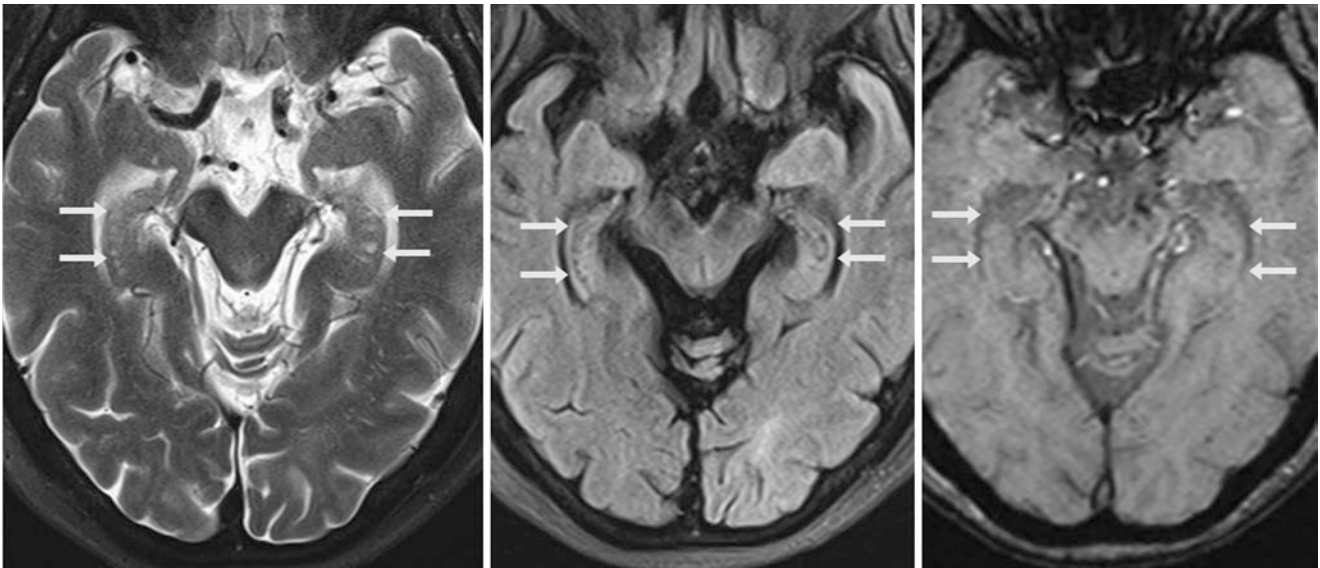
A 59 year old who had a history of dementia had the incidental finding of a string of bilateral hippocampal cysts (*arrows*) on 1.5 T MRI axial T2WI (*left*), which suppress on FLAIR (*middle*) and are invisible on SWI (*right*)
